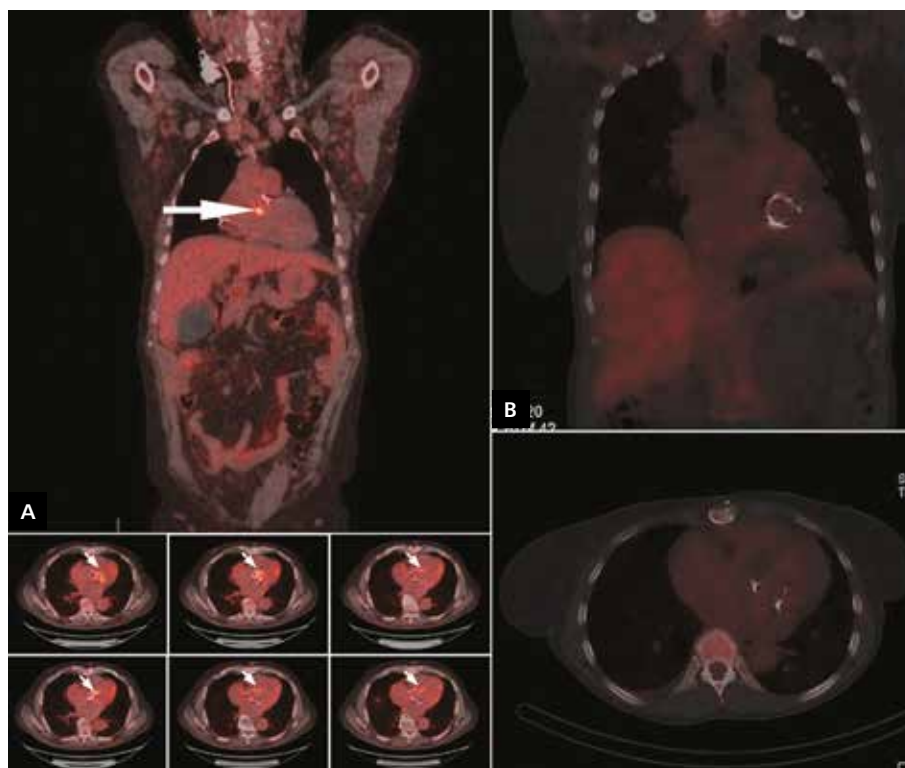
A. Positron emission tomography/computed tomography (CT) after injection of 332 MBq 18F-FDG; increased metabolic activity in the aortic valve replacement (arrows) consistent with active endocarditis with no apparent aortic root involvement. The low-dose non-contrast CT data was used for attenuation correction and anatomic localisation. Reconstructed images in the axial and coronal views were interpreted; B. 99mTc-HMPAO-labelled leukocyte single-photon emission computed tomography — negative for prosthetic valve endocarditis
